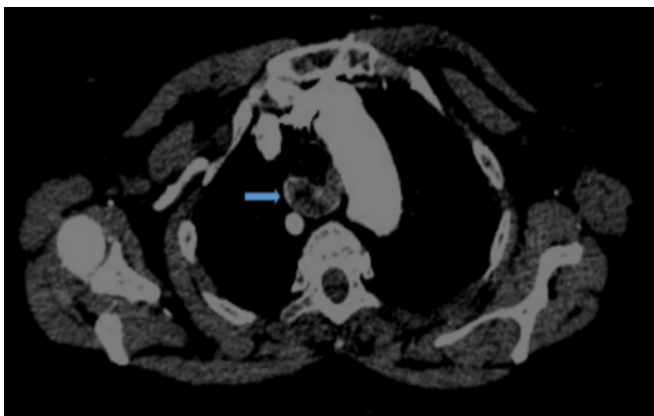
Thorax CT showing the parathyroid adenoma (arrow).
